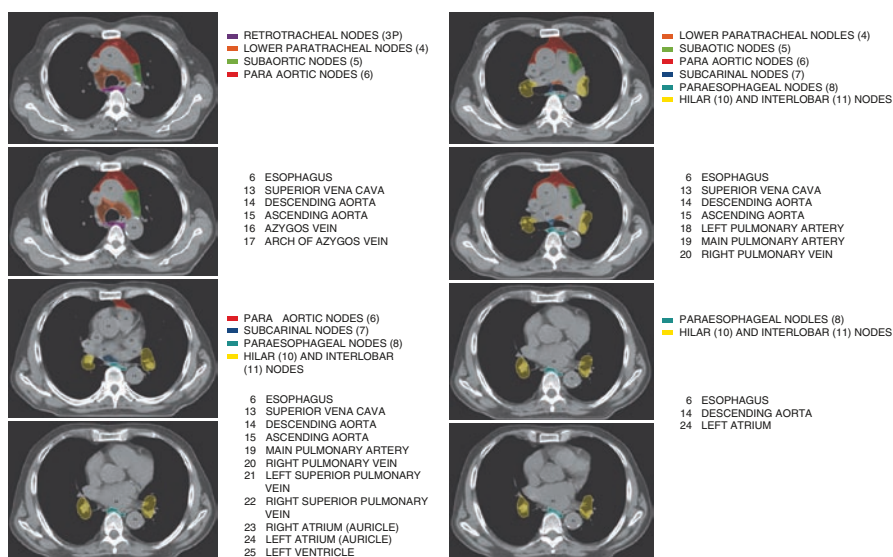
Intrathoracic lymph nodes in serial axial CT slices
